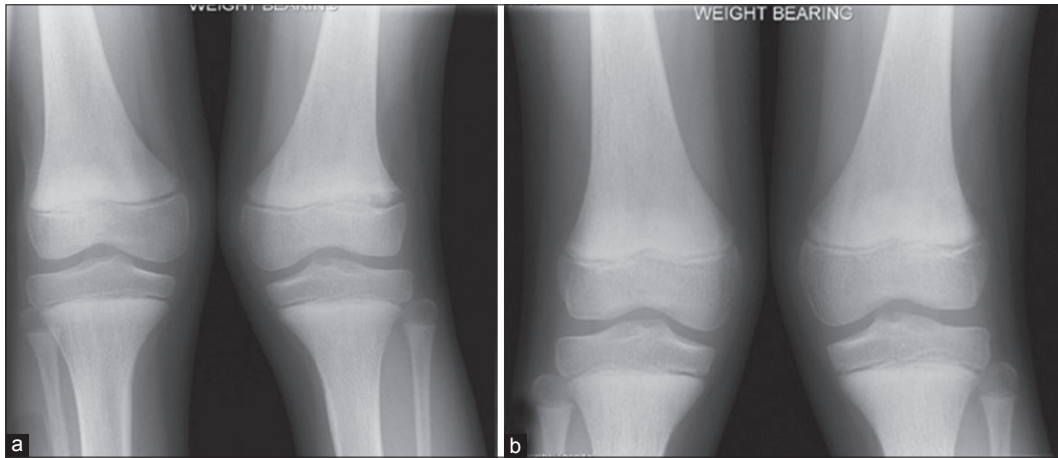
Radiograph of knee joint (anteroposterior view) showing (a) widening of distal femoral physis and ossification of metaphysis with valgus deformity in left knee at 4 months after the initial presentation (b) disappearance of the distal femoral physal changes after the treatment with alfacalcidol
